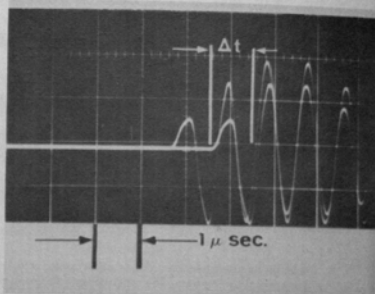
Received waveforms of ultrasonic pulse transmitted through water and through breast tissue.
